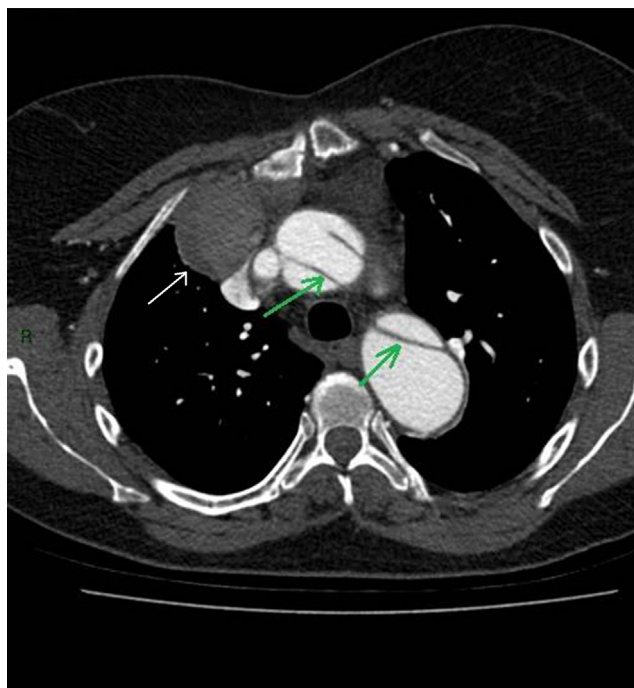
Transverse image from CT angiogram. The 5-cm RIMA pseudoaneurysm is seen anterior and to the right of the ascending aorta (white arrow). The residual dissection flap is seen within the ascending and descending aorta (green arrows).
